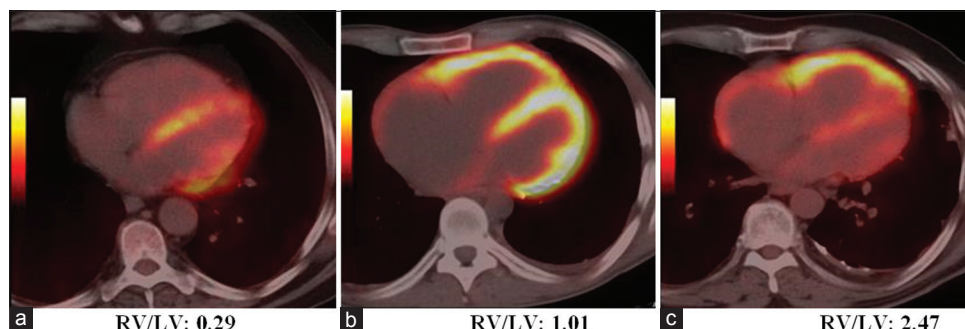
Sample of FDG PET uptake (a, b and c)
